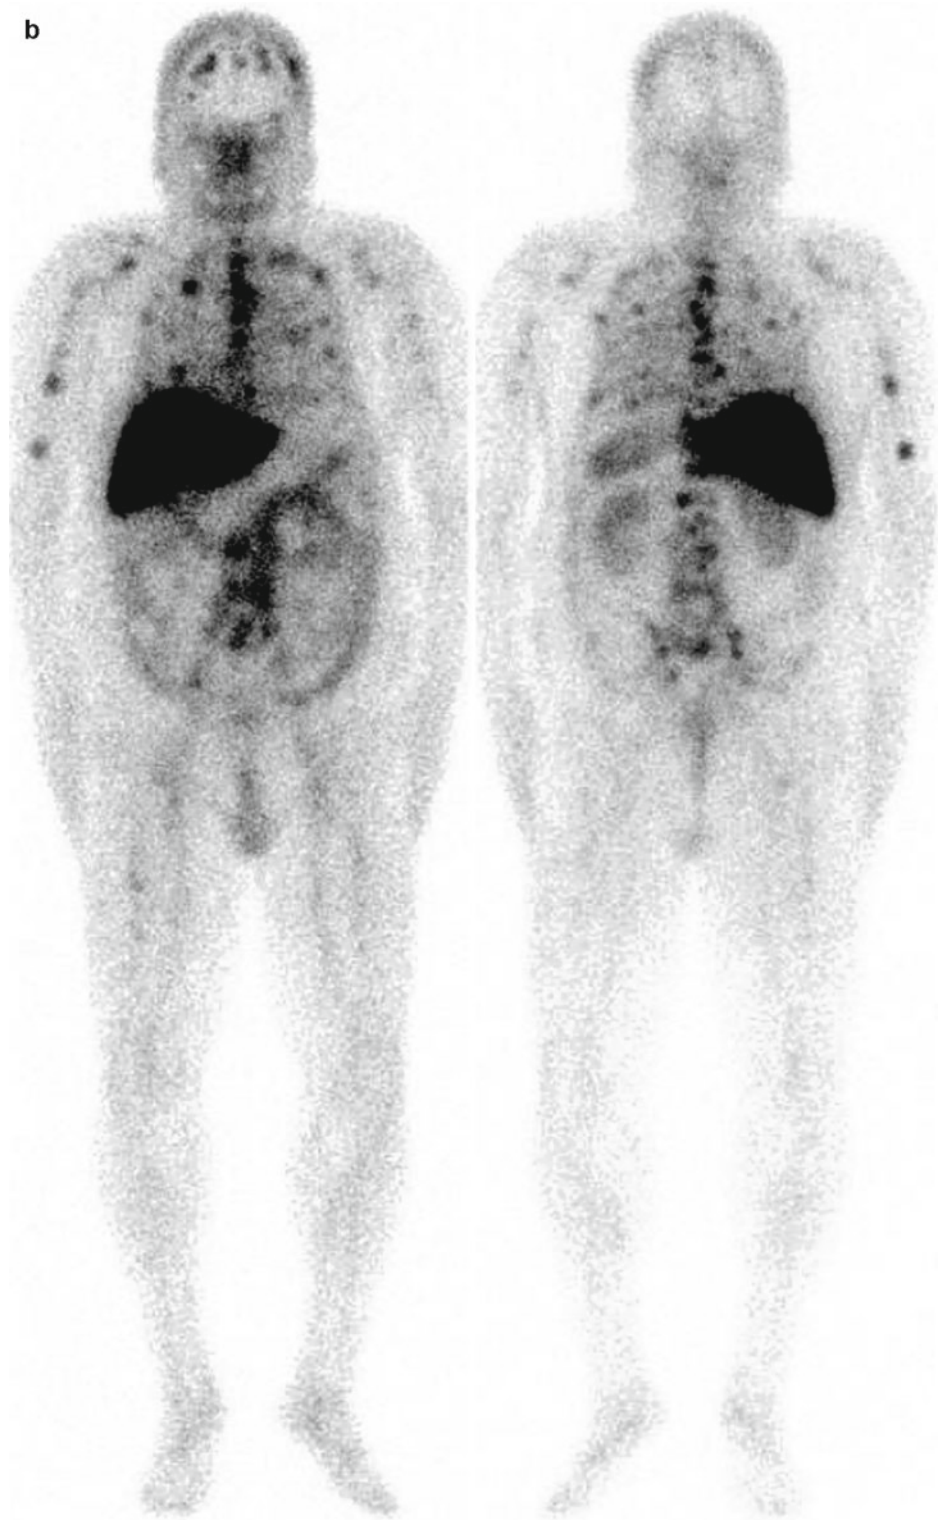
(a) Anterior and Posterior planar ^{99m}Tc -MDP Bone Scan demonstrating multifocal osseous metastasis. (b) Anterior and Posterior planar ^{177}Lu -huJ591 demonstrating excellent tumor targeting to sites clearly seen on the bone scan and a few that are not clearly identified on bone scan. Abdomino-pelvic uptake was suspicious for soft tissue metastasis. (c) Axial (*top*) and Sagittal reconstruction after treatment dose of ^{177}Lu -huJ591 SPECT/CT demonstrating localization in retroperitoneal lymph nodes as well as lumbar vertebrae
